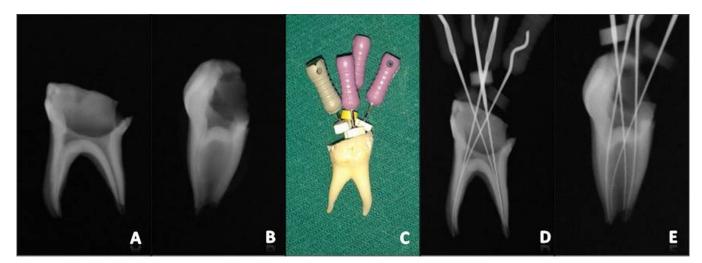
(a and b) Preinstrumentation radiographs, (c) real-tooth length determination, (d and e) working length corresponding to the real tooth length
